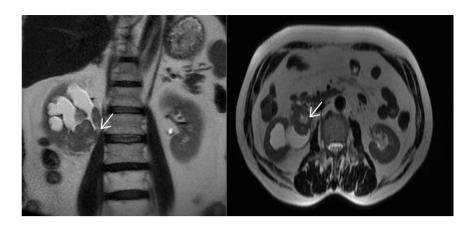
Coronal and axial MRI demonstrating right renal mass MRI: Magnetic resonance imaging
